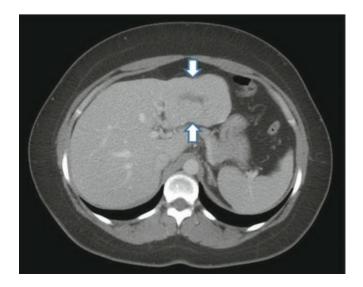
A 32-year-old, previously healthy female with acute lower abdominal pain admitted for acute abdominal CT, which showed acute appendicitis. As incidental finding, a 7×6 cm solid, slightly lobulated lesion of the left lobe of the liver was found. The lesion appeared isoattenuating with the liver in the portal phase (*arrows*) and showed a central scar suggestive of, but not proving, focal nodular hyperplasia (FNH). It could not be confidently classified on single-phase CT, but FNH was confirmed by subsequent liver MRI
